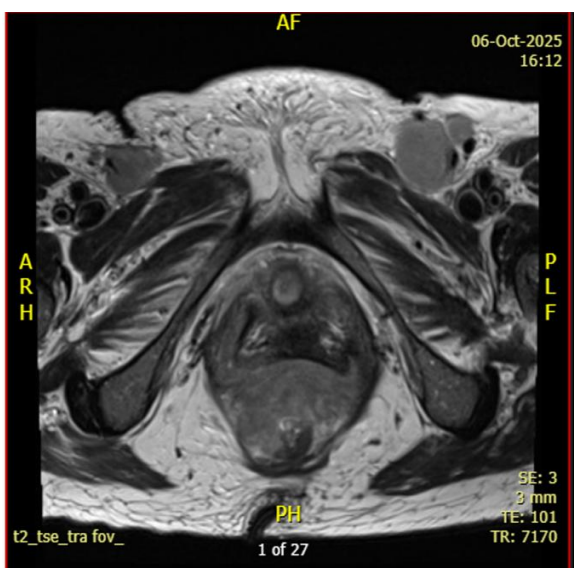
MRI axial view showing enlarged inguinal nodes (left and right).
